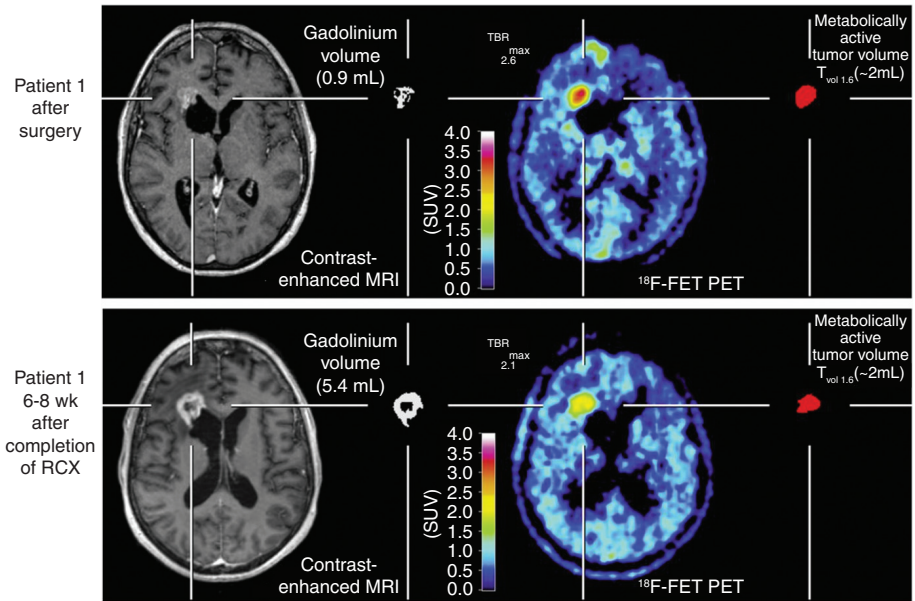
^{18}F -FET-PET in a 59-year-old woman with glioblastoma. Brain imaging was performed after surgery (upper panel; MRI-/FET-1) and 6–8 weeks after completion of radiochemotherapy (lower panel; MRI-/FET-3). Contrast-enhanced MRI with corresponding contrast-enhanced volume is shown on the left and ^{18}F -FET PET with corresponding metabolic volume on the right. Enlargement of contrast-enhanced volume on MRI 6–8 weeks after completion of radiochemotherapy (lower panel) is suggestive of tumor progression, whereas ^{18}F -FET PET conversely indicates responsiveness with decreasing amino acid uptake (reduction of TBRmax) and unchanged metabolic volume. (Adapted from *J Nucl Med* 2012;53:1048–1057. Copyright: Society of Nuclear Medicine and Molecular Imaging, Inc. Reproduced with Permission.)
